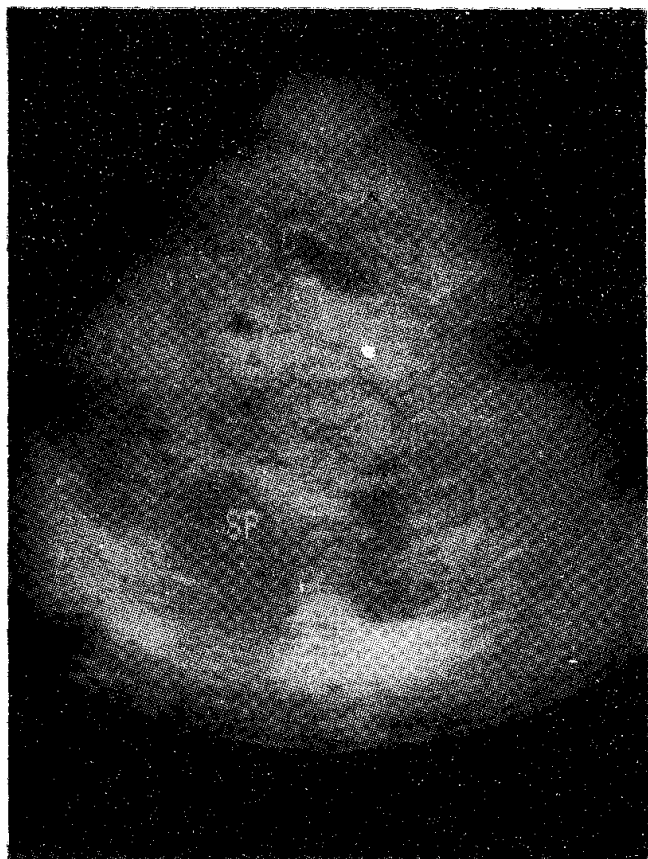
Residual cyst as seen on ultrasound scan immediately after the percutaneous drainage, Cyst - C, Spine - SP, Drainage tube - D.
